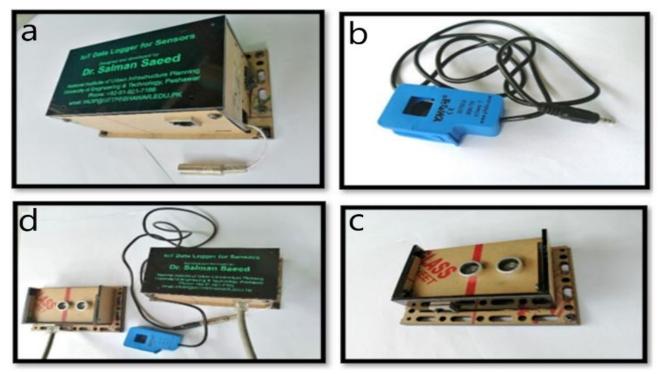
Equipment Used; a. IoT Data Logger for Sensors, b. Split-core Current Transformer, c. Ultrasonic Sensor, d. The Combination of Parts
